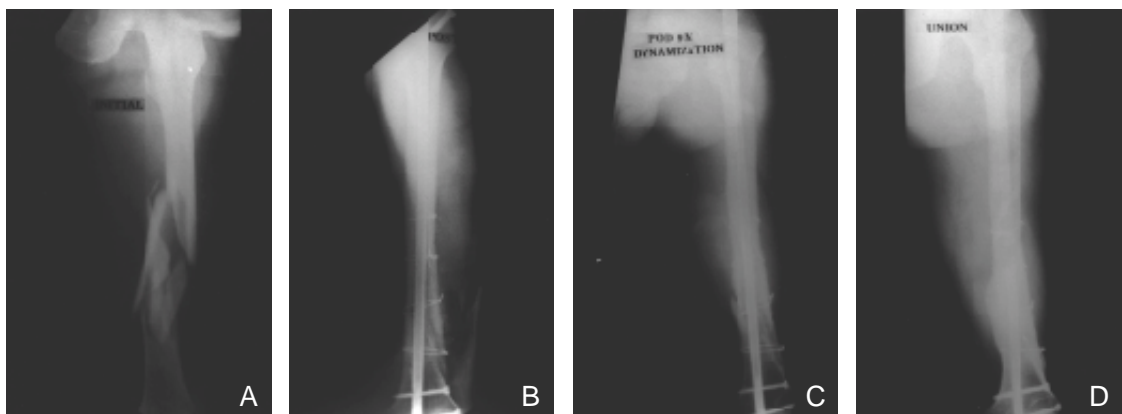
Serial radiographs of 37 year-old male patient treated with open interlocking intramedullary nailing.
